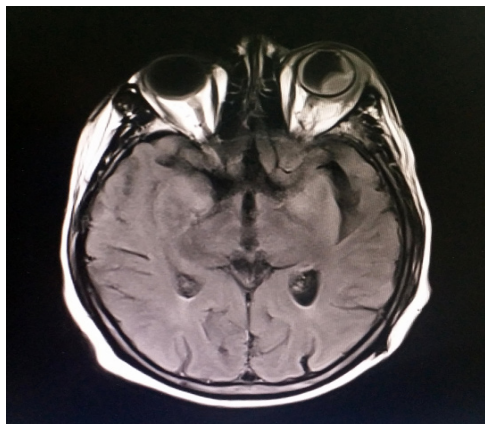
CT orbit (axial view) showed the left eye choroidal lesion was abscess in nature and retro-orbital tissue was inflamed
